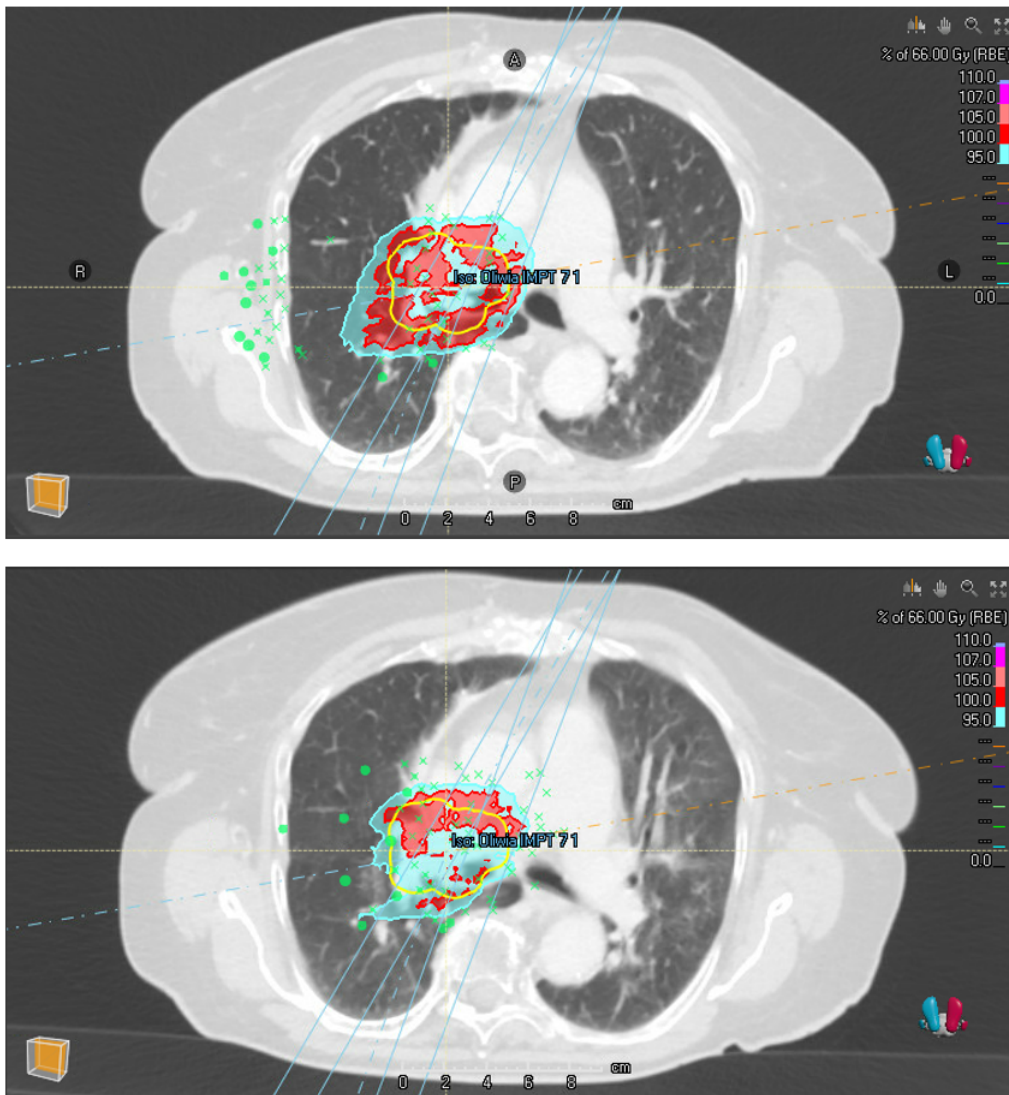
Dose distribution in a single CT slice for patient 7 using the $IMPT_{4.5\%}$ plan. The upper image shows the initial (CT 1) calculation and the image below shows dose distribution recalculated on the control CT. The upper image shows that the prescribed dose (red) is delivered to a large area outside of the ICTV_u border (yellow). This can be used to explain the low conformity index. Image below it shows how the dose distribution is affected by the changes in the lung tissue. Specifically, the 80° beam (marked with the orange dash-dotted line) seems to be affected by the changes in the left lung (right side of the image).
